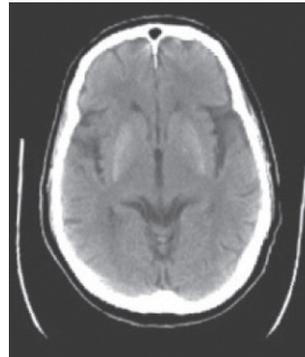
CT Brain (p) showing hyper densities in bilateral basal ganglia.
